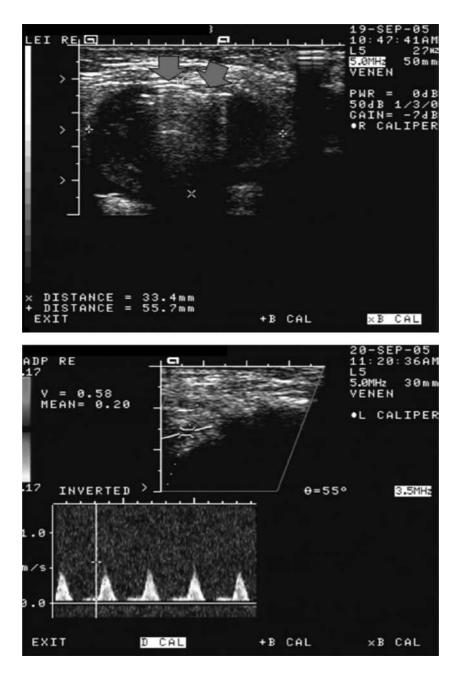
Ultrasound B-image immediately after thrombin injection and complete thrombosis of the pseudoaneurysms; the hyperechogenic reflex indicates the site of the thrombin depot (red arrows, upper image). The lower image shows the ultrasound Doppler signal of the ipsilateral arteria dorsalis pedis.
